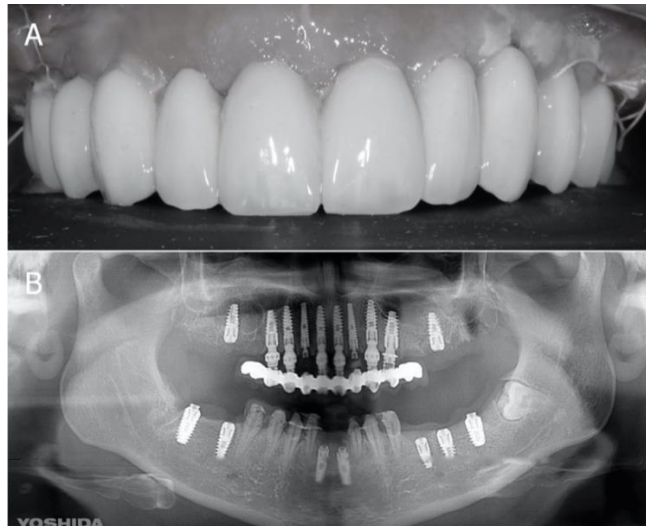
(A) The metal reinforced provisional restoration in situ, and (B) the panoramic control radiograph of the placed implants.
